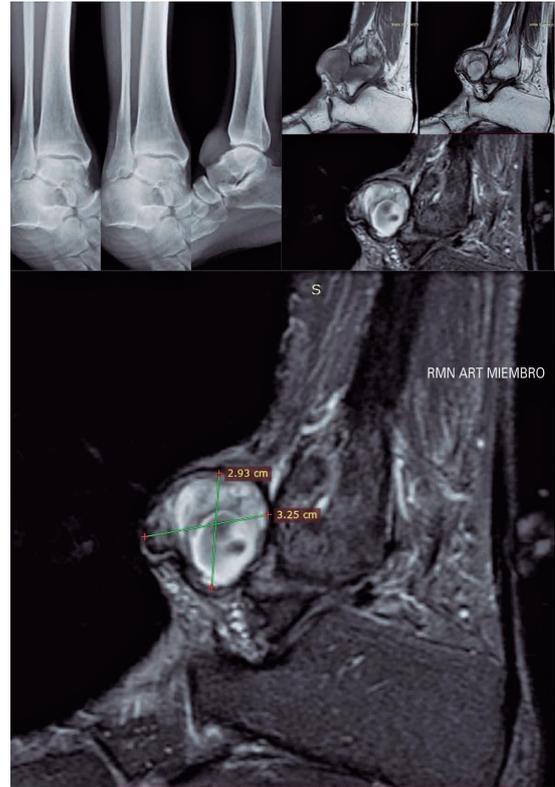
Radiologic images. A) Ankle radiograph showing soft tissue mass in lateral view. A) Nuclear magnetic resonance imaging of the ankle revealing a multilocular, heterogeneous mass.
